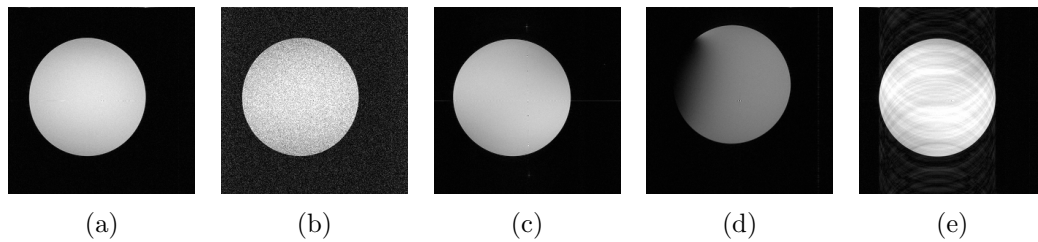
Noise and different artifacts in MR images (source: <http://chickscope.beckman.illinois.edu/roosts/carl/artifacts.html>) (a) Reference image, (b) Random noise in a low signal-to-noise ratio acquisition (c) Geometric distortion due to B_0 field inhomogeneity, (d) Geometric distortion due to RF field inhomogeneity, (e) Motion artefact
